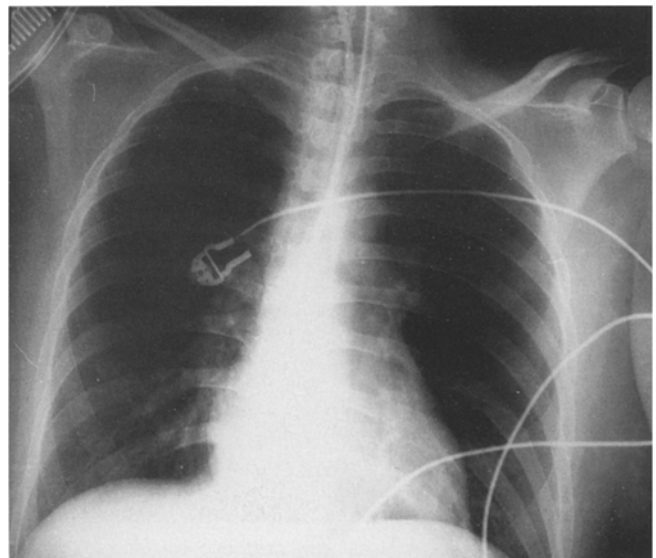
Chest X-ray at Day 4 showing no abnormality whereas severe hypoxemia occurred
